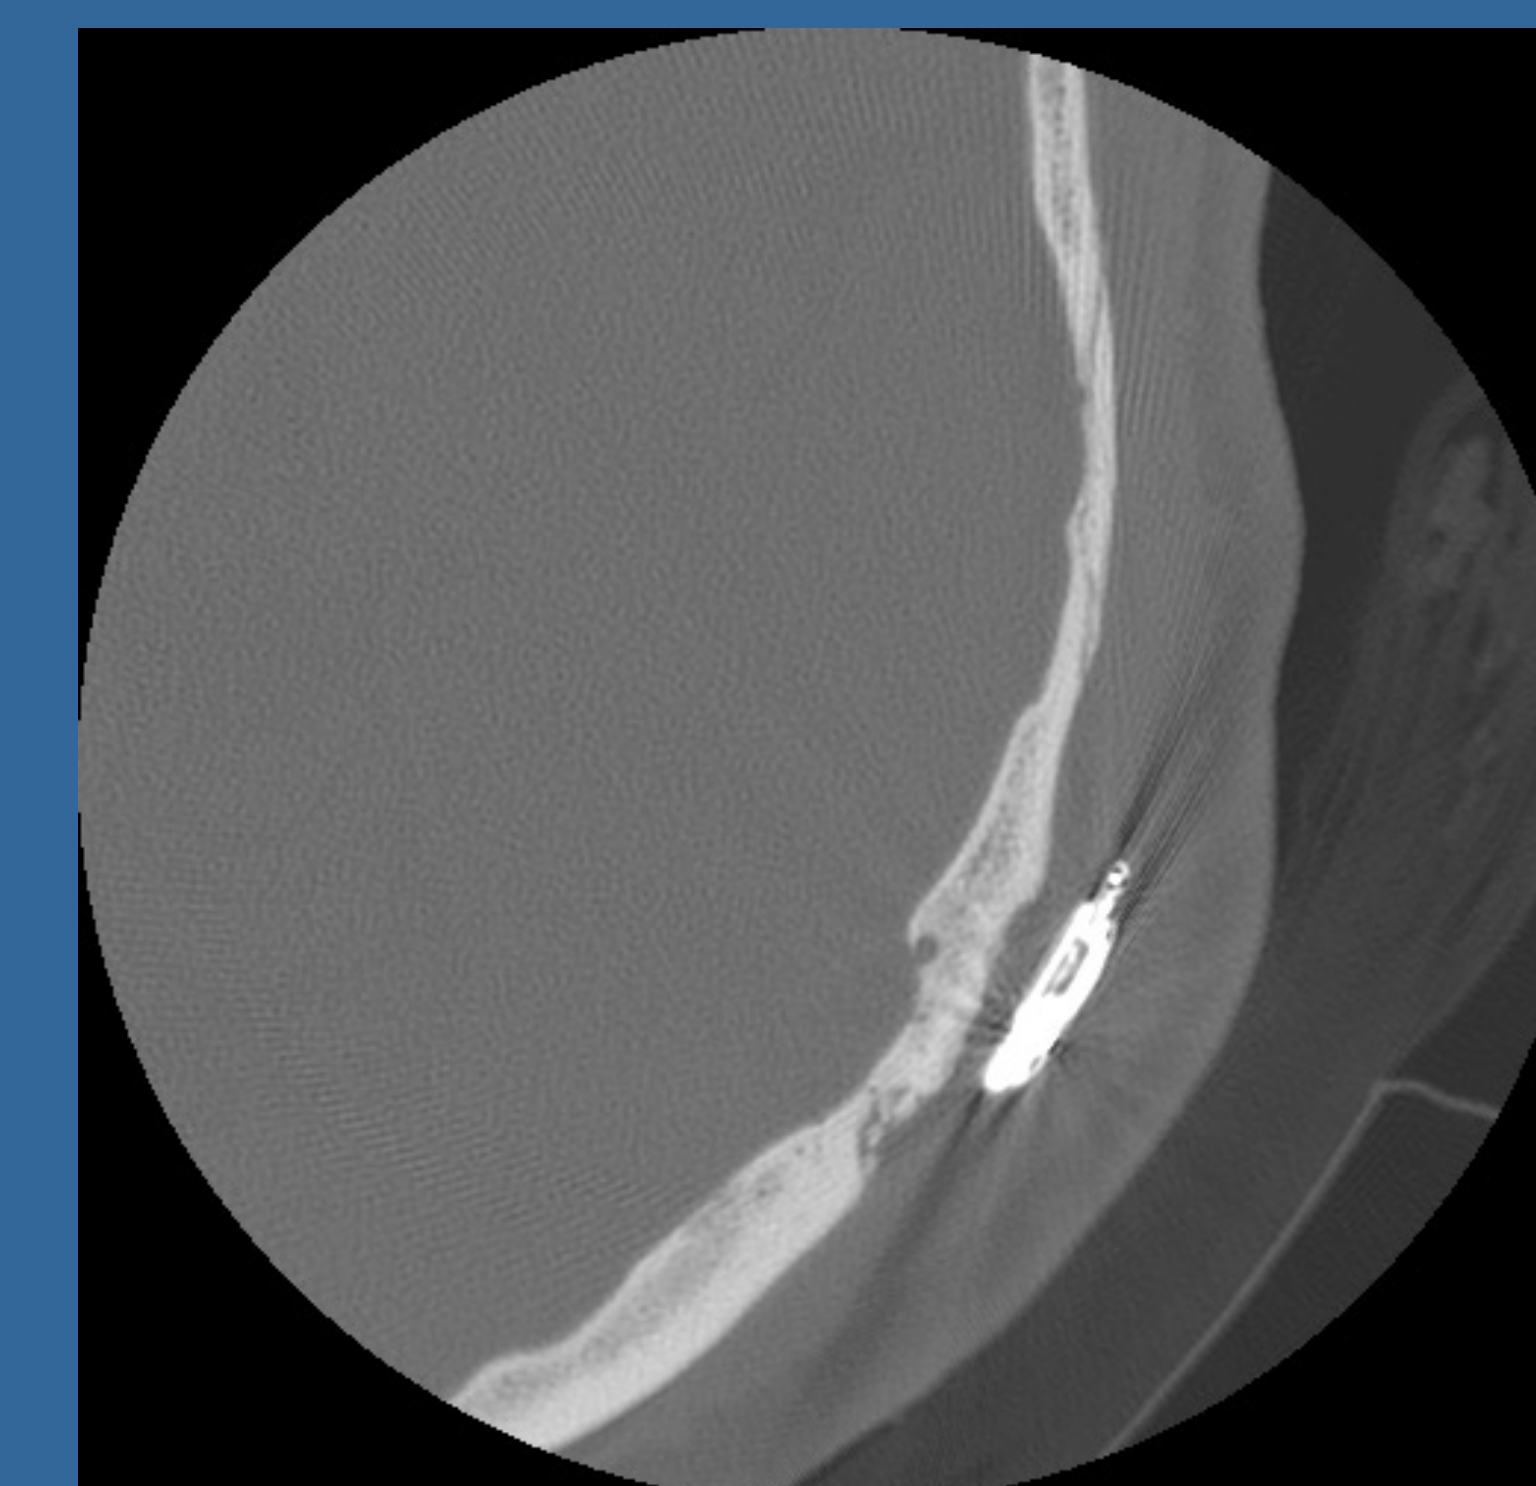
Postoperative CT temporal bone w/o contrast suggests shift and movement of implant away from skull
